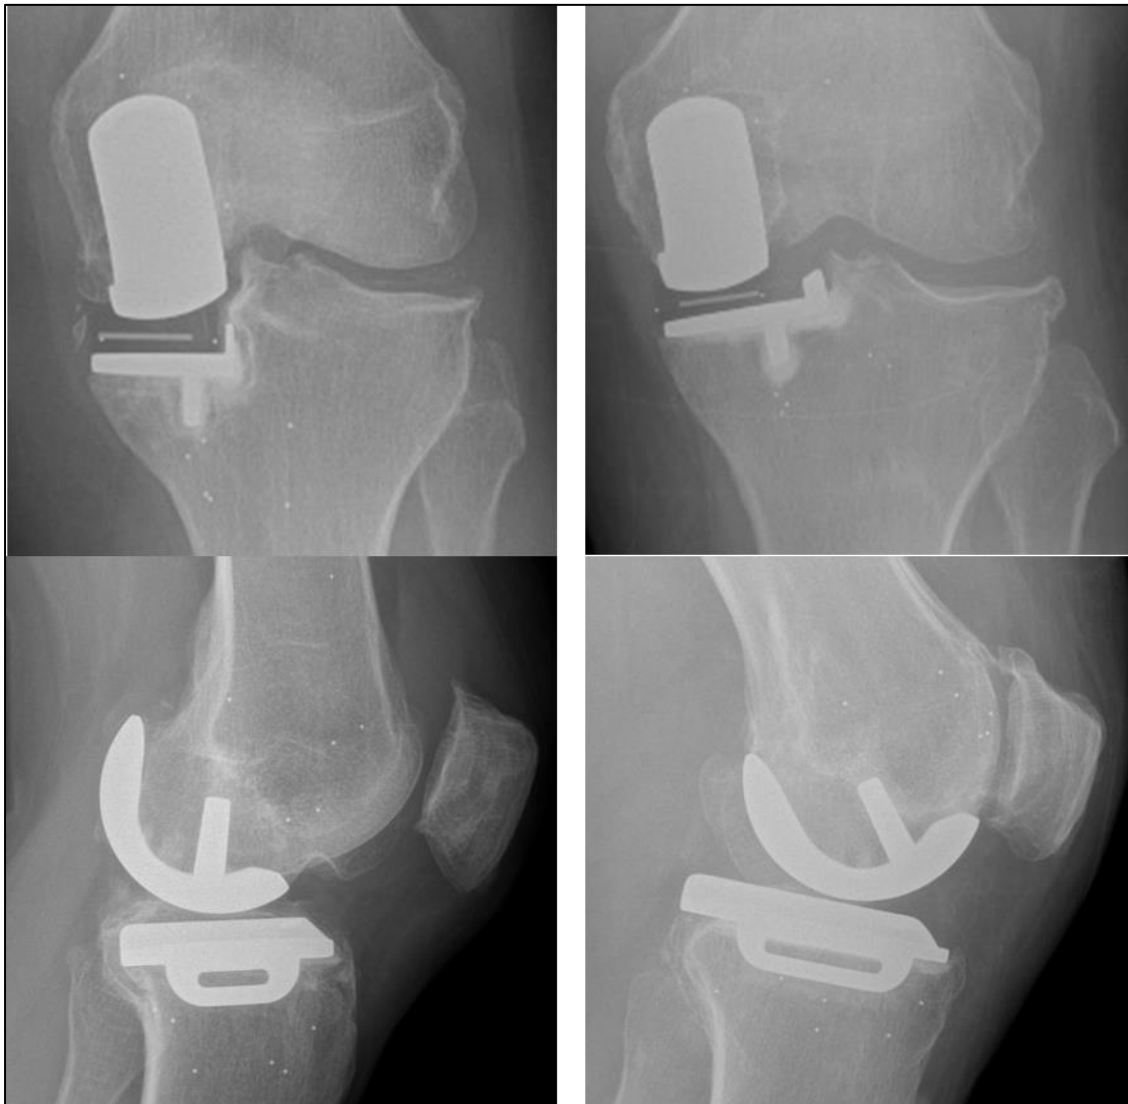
10-year anteroposterior (top) and lateral (bottom) radiographs of cemented Oxford Unicompartmental Knee Replacements with substantial five to 10-year tibial migration. Left: Radiographs of the patient with five to 10-year MTPM 2.22 mm. Right: 10-year radiograph of the other case with substantial late migration with five to 10-year MTPM 0.34 mm.
